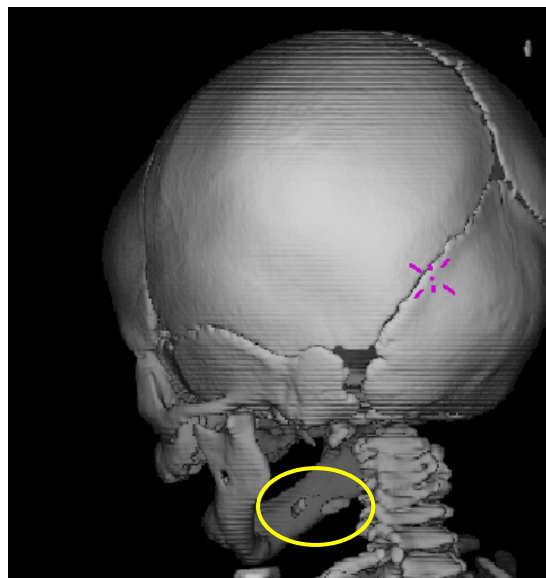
A CT scan showing the absence of ossification of the body of the hyoid bone in CLP patients (posterior view).
